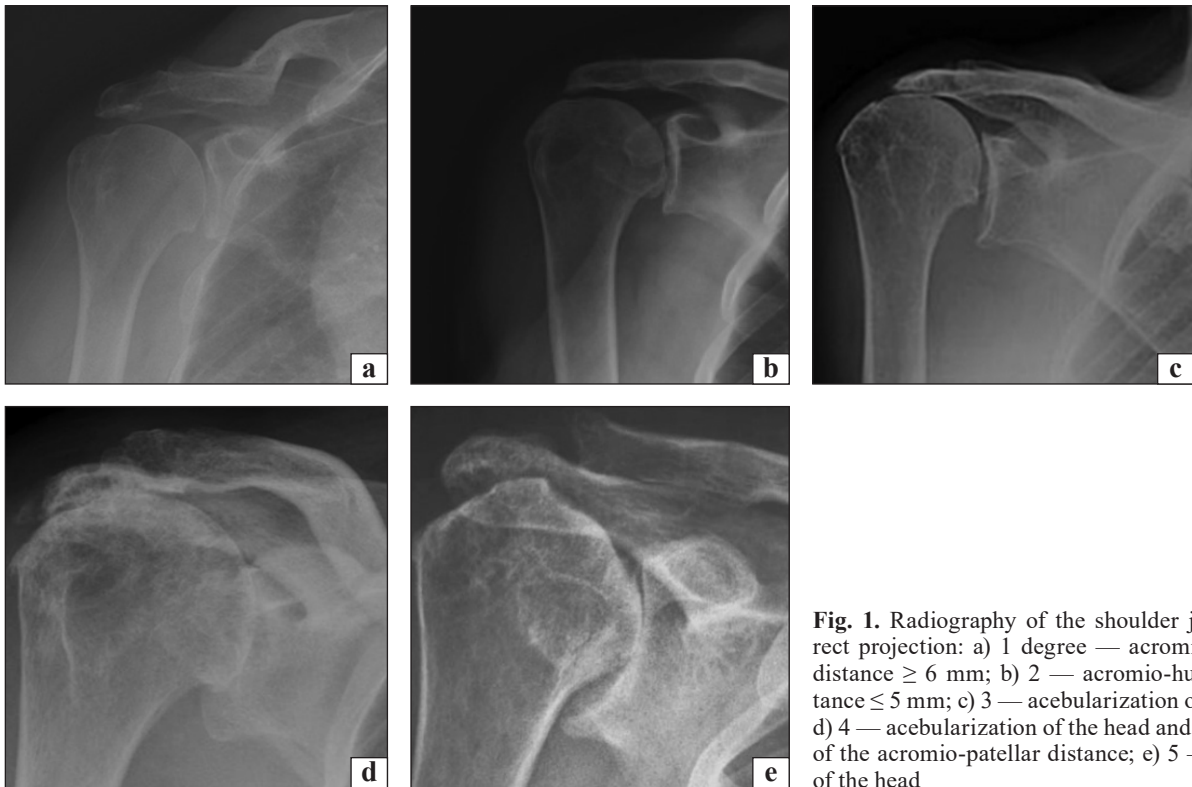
Radiography of the shoulder joint in direct projection: a) 1 degree — acromio-humeral distance ≥ 6 mm; b) 2 — acromio-humeral distance ≤ 5 mm; c) 3 — acbularization of the head; d) 4 — acbularization of the head and narrowing of the acromio-patellar distance; e) 5 — collapse of the head
